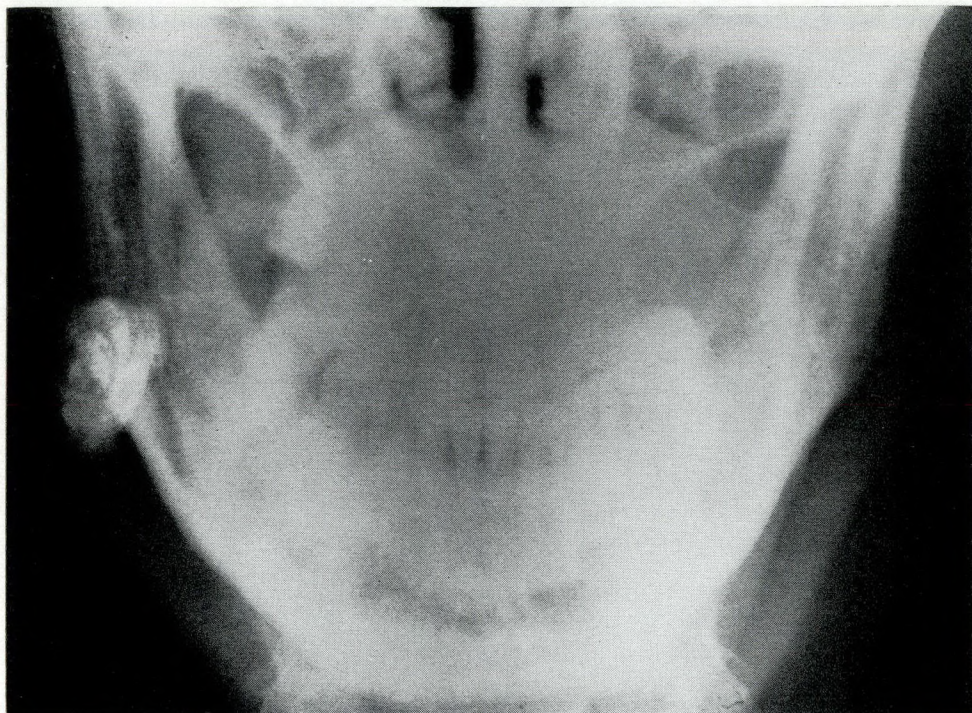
Radiograph showing osteoma of right mandible.
